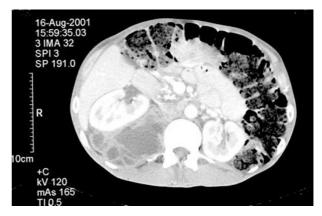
CT scan showing right large iliopsoas abscess, with anterior displacement of the right kidney.
